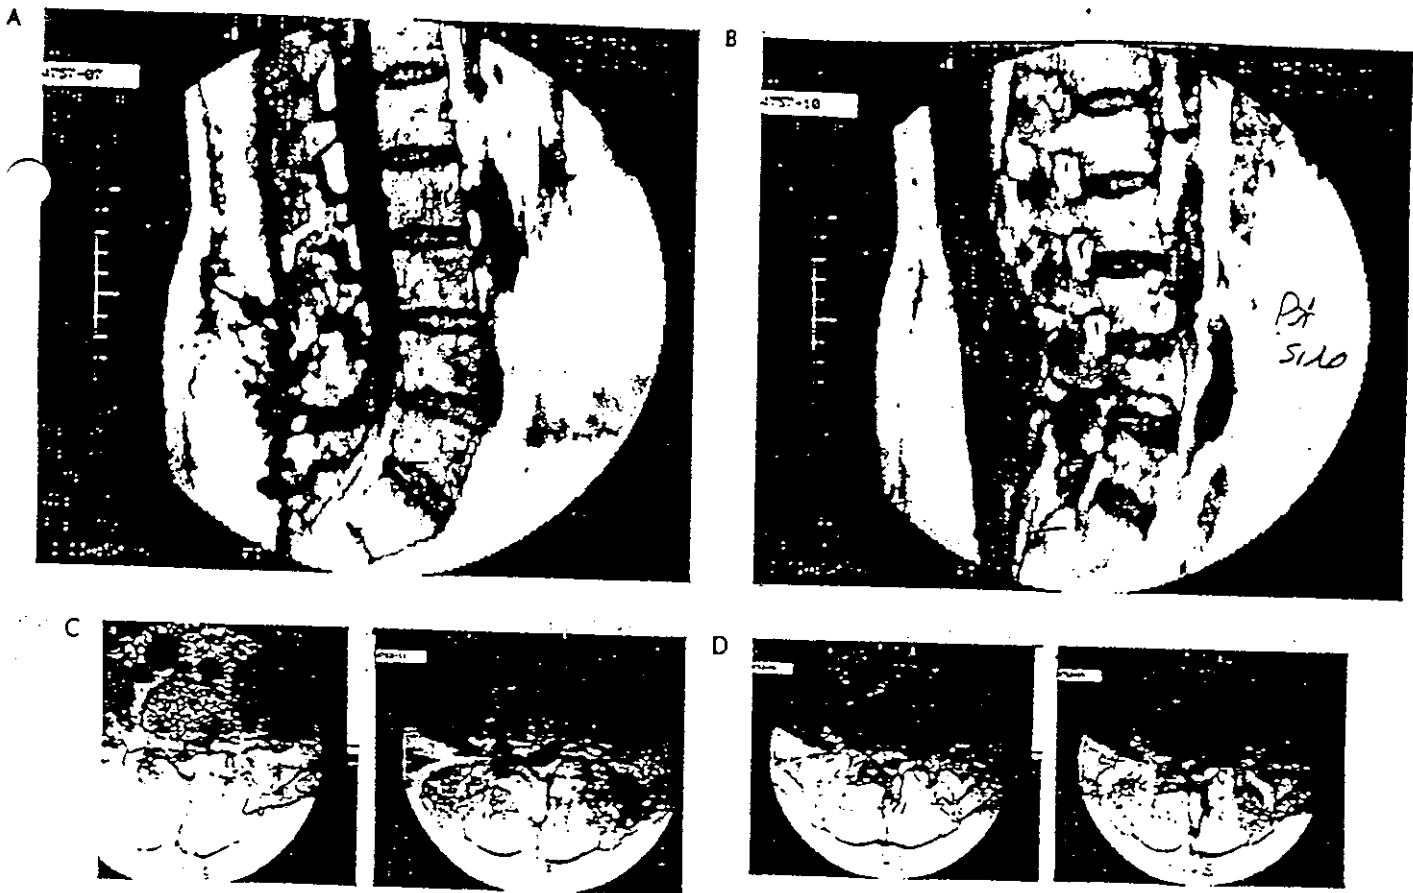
T₁-weighted MRI scan through the lumbar spine in December 1987. A, Midline sagittal image. B, Right-side parasagittal image. C, Axial image at L₄ disc level. D, Axial image at L₅ disc level. Note the presence of scar tissue with distortion of nerve roots, as well as degenerative changes and posterior protrusion of the L₄ and L₅ disc.
